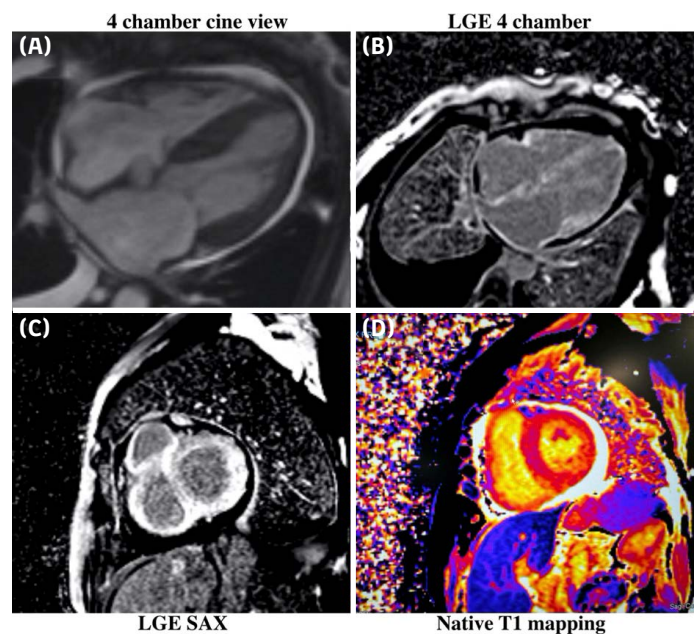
Cardiac magnetic resonance imaging (MRI): (A) Apical four-chamber cine view; (B) Apical four-chamber late gadolinium enhancement (LGE) view; (C) Left ventricular (LV) short-axis late gadolinium enhancement (LGE) view; (D) Native T1 mapping.
